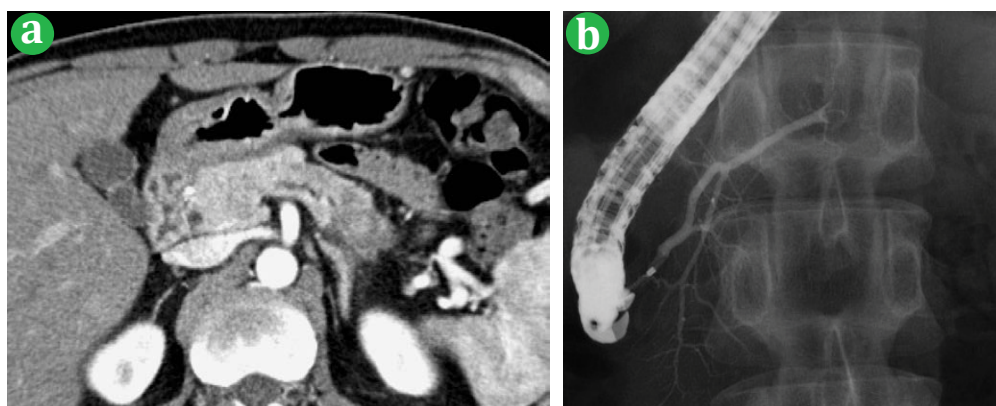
Tumor occupying the pancreatic duct. This lesion has a worse prognosis. (Non-functional tumor, NEC). (a). Dynamic computed tomography scan shows a hypo-enhanced tumor in the pancreatic duct. (b). Endoscopic retrograde cholangiopancreatography also shows a filling defect in the pancreatic duct.
